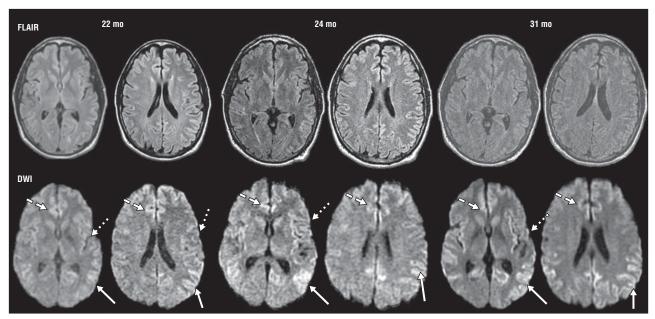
Axial fluid-attenuated inversion recovery (FLAIR), diffusion weighted imaging (DWI)/magnetic resonance imaging scans at 22, 24, and 31 months after onset showing extensive left greater than right cortical ribboning (hyperintensity) in the insula and peri-insular cortex (dotted arrow) and the cingulate gyrus (dashed arrow) and left greater than right cortical ribboning in the parietal-temporal cortex (angular gyrus; solid arrow). There is also a slight bilateral caudate hyperintensity. The apparent diffusion coefficient map confirmed restricted diffusion (not shown). Images are per radiological convention; thus, right is left and left is right.
